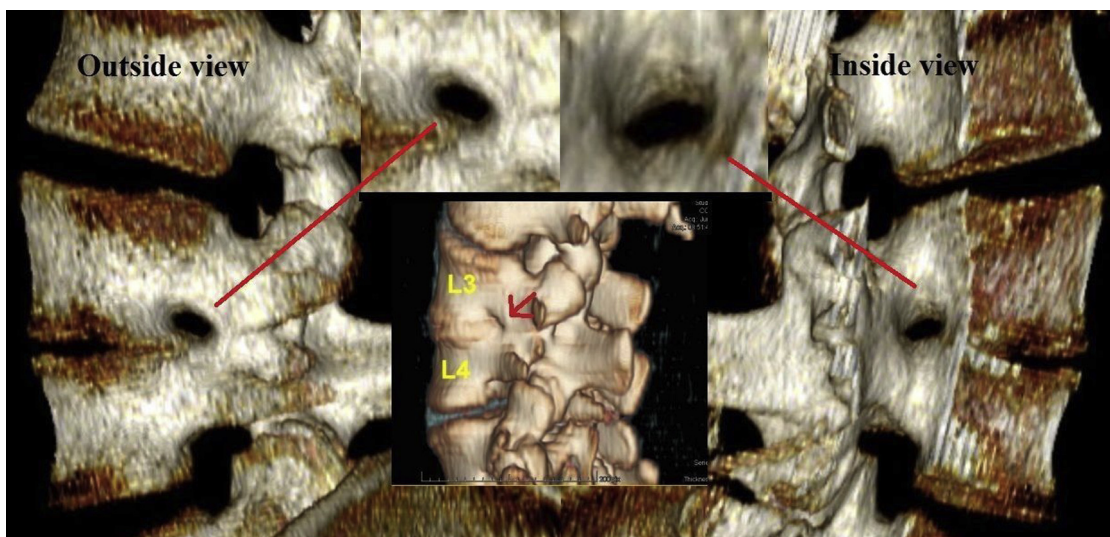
Three-dimensional computed tomography reconstruction: The outside view (posterolateral incidence) confirms the stenosis of the external foraminal ostium and the L3–L4 somatic synostosis. The outside view highlights an internal foraminal ostium of normal dimensions, creating a funnel-like image. The unsegmented somatic pedicular transverse lamellar bony bar (center-red arrow).
